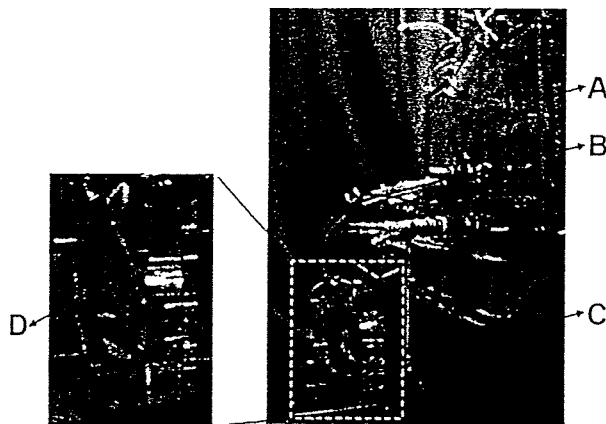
Configuration of the model pump. The model pump was made of acrylic resin to allow visualization of the flow velocity from the blood pump, the model pump had the same configuration as the PVAD. A: Donovan mock circulatory loop tester; B: ultrasound flow meter; C: model pump; D: valve mount.
